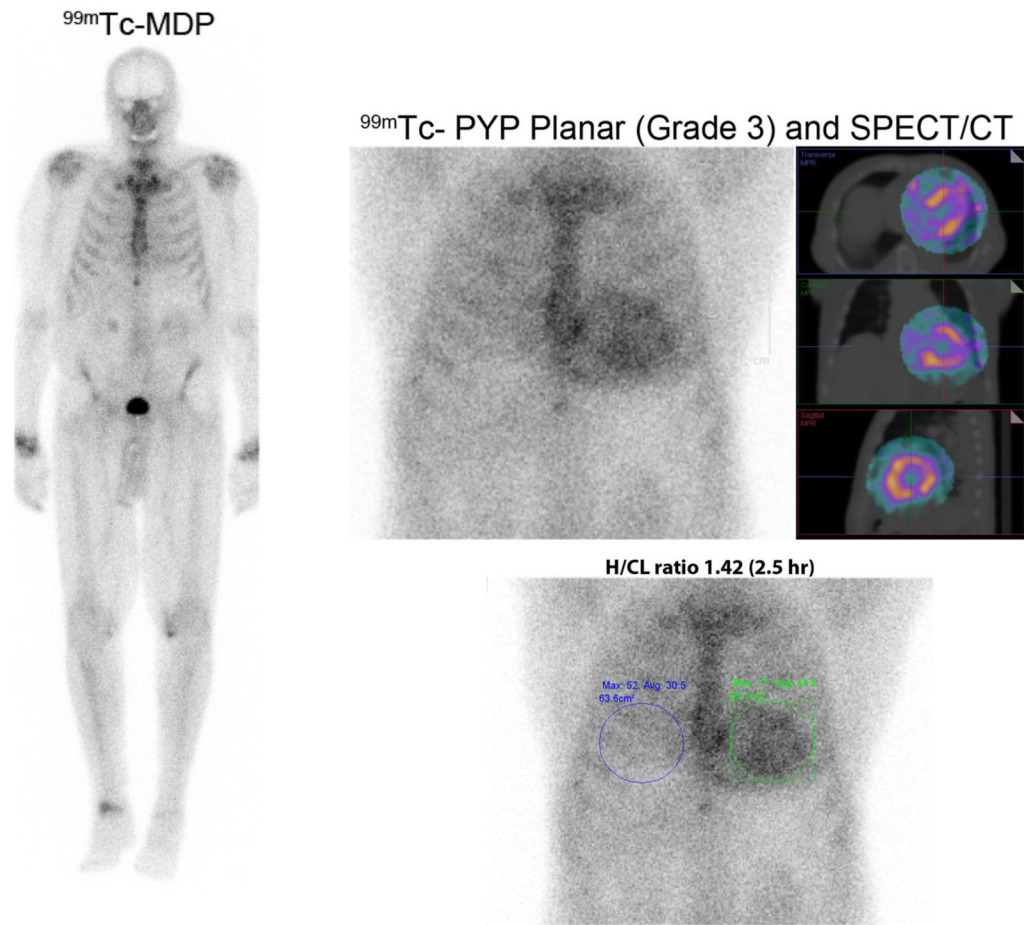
^{99m}Tc -MDP and ^{99m}Tc -PYP images in cardiac ATTR amyloidosis. Images of an 86-year-old man with prostate cancer and a ^{99m}Tc -MDP scan showing no myocardial radiotracer uptake. He presented a month later with heart failure, and echocardiography revealed classic features of cardiac amyloidosis. A clonal abnormality was excluded by serum and urine immunofixation, and serum-free light chain levels. A ^{99m}Tc -PYP scan was performed using chest planar and SPECT imaging 2.5 hours after injection of radiotracer; Grade 3 myocardial uptake on ^{99m}Tc -PYP planar, and SPECT with a heart-to-contralateral ratio of 1.42 on planar images (1.3 abnormal for late images) diagnosed cardiac ATTR amyloidosis.
